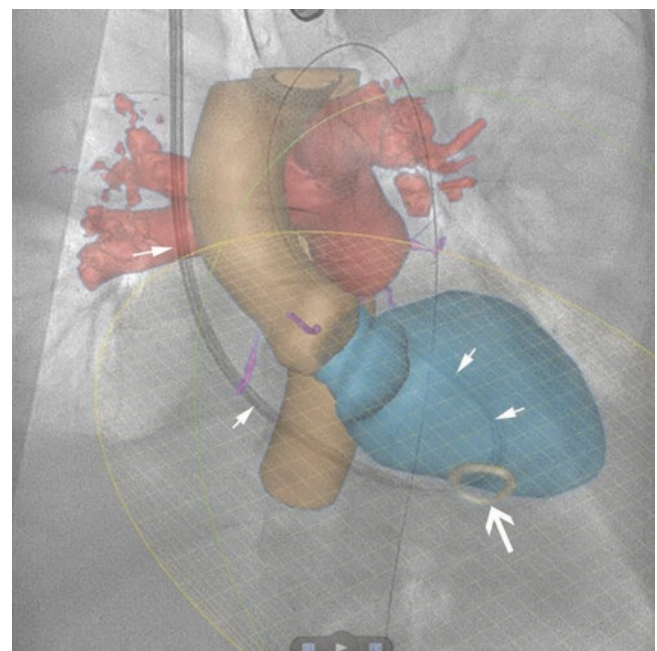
CTA-fluoroscopy fusion—advancing delivery sheath. Delivery sheath is introduced through the VSD (large white arrow) into the left ventricle (small white arrows) using the AV rail and is advanced into the aorta (Video 3)
